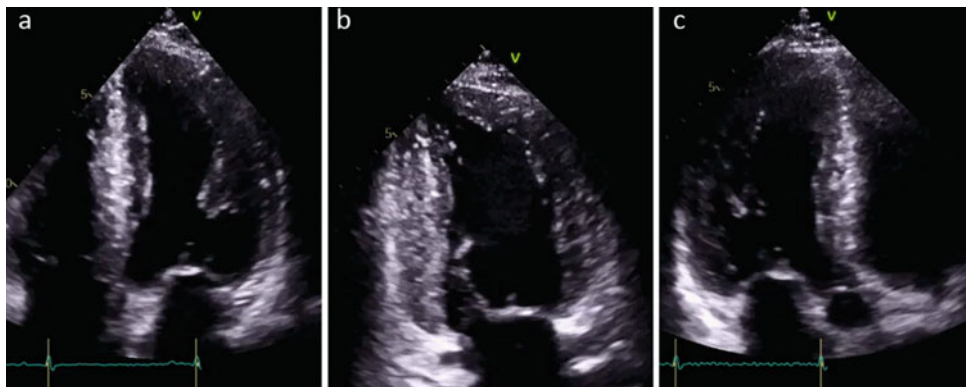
a Apical four-chamber view. b Apical two-chamber view. c Apical three-chamber view. LV EF = 65%; left atrial volume = 41 ml/m² consistent with mildly dilated left atrium. No systolic motion noted. LVEF = left ventricular ejection fraction. See Video 18.4
